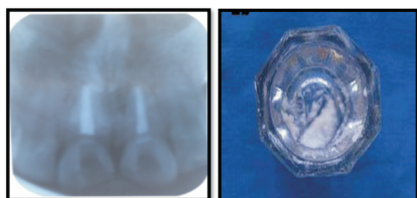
Radiograph showing 3mm gutta percha removal after root canal treatment.
